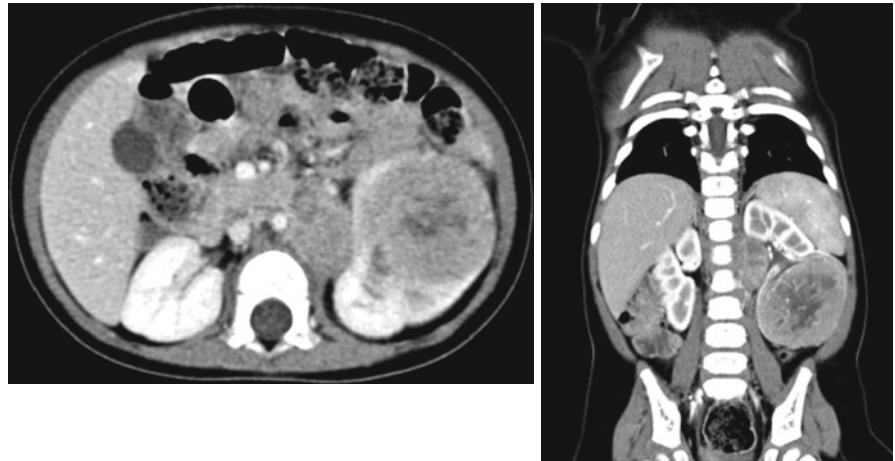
Post-contrast CT imaging of: (a) angiomyolipoma (male, 13 year-old); (b) primitive neuroectodermal tumor (female, 15 year-old); (c) Wilms tumor (male, 4 year-old); (d) clear cell sarcoma (male, 3 year-old); (e) 6-year-old female who
